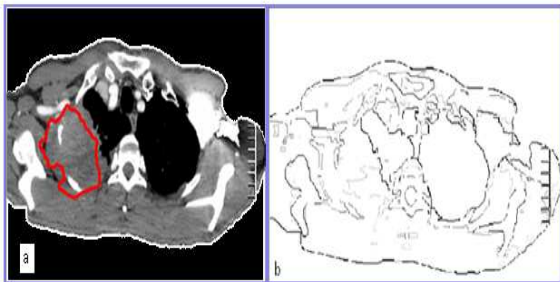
(a) CT image of patient (P_1) with Caselle segmentation algorithm [10] to highlight cancerous tissues at advanced stage, (b) edges and borders of the original plot for the patient.
